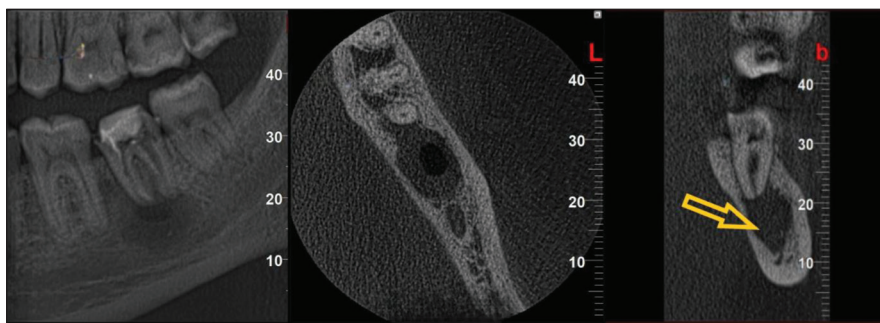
Representative sections from CBCT made right after the first visit: (a) coronal plane; (b) axial plane presenting well-defined radiolucency inside the bigger, diffuse radiolucency; (c) sagittal plane presenting breakdown of the roof of the mandibular canal
